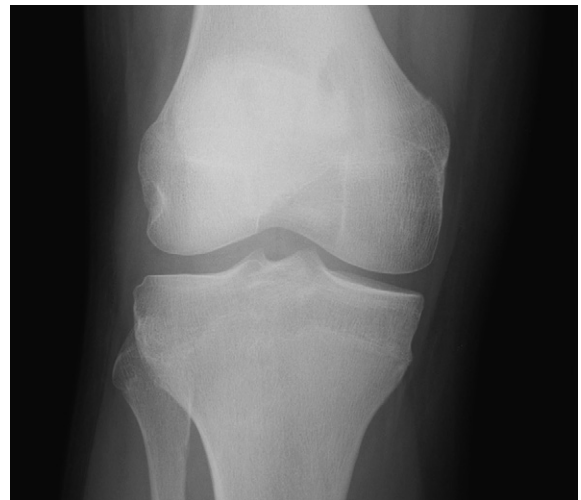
Plain radiograph showing radio-lucent lesion with a well-defined border in the medial aspect of the distal right femur.
